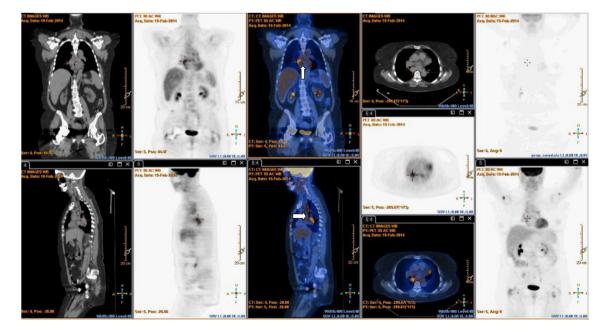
18FDG-PET/CT showed focus of FDG hypermetabolism at mediastinal lymph node.
